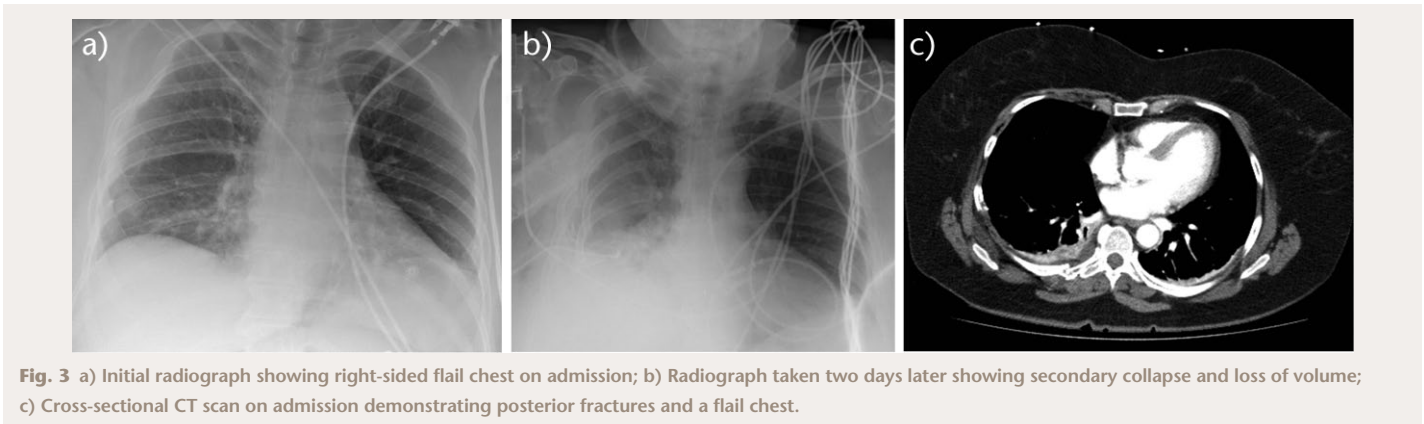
a) Initial radiograph showing right-sided flail chest on admission; b) Radiograph taken two days later showing secondary collapse and loss of volume; c) Cross-sectional CT scan on admission demonstrating posterior fractures and a flail chest.
